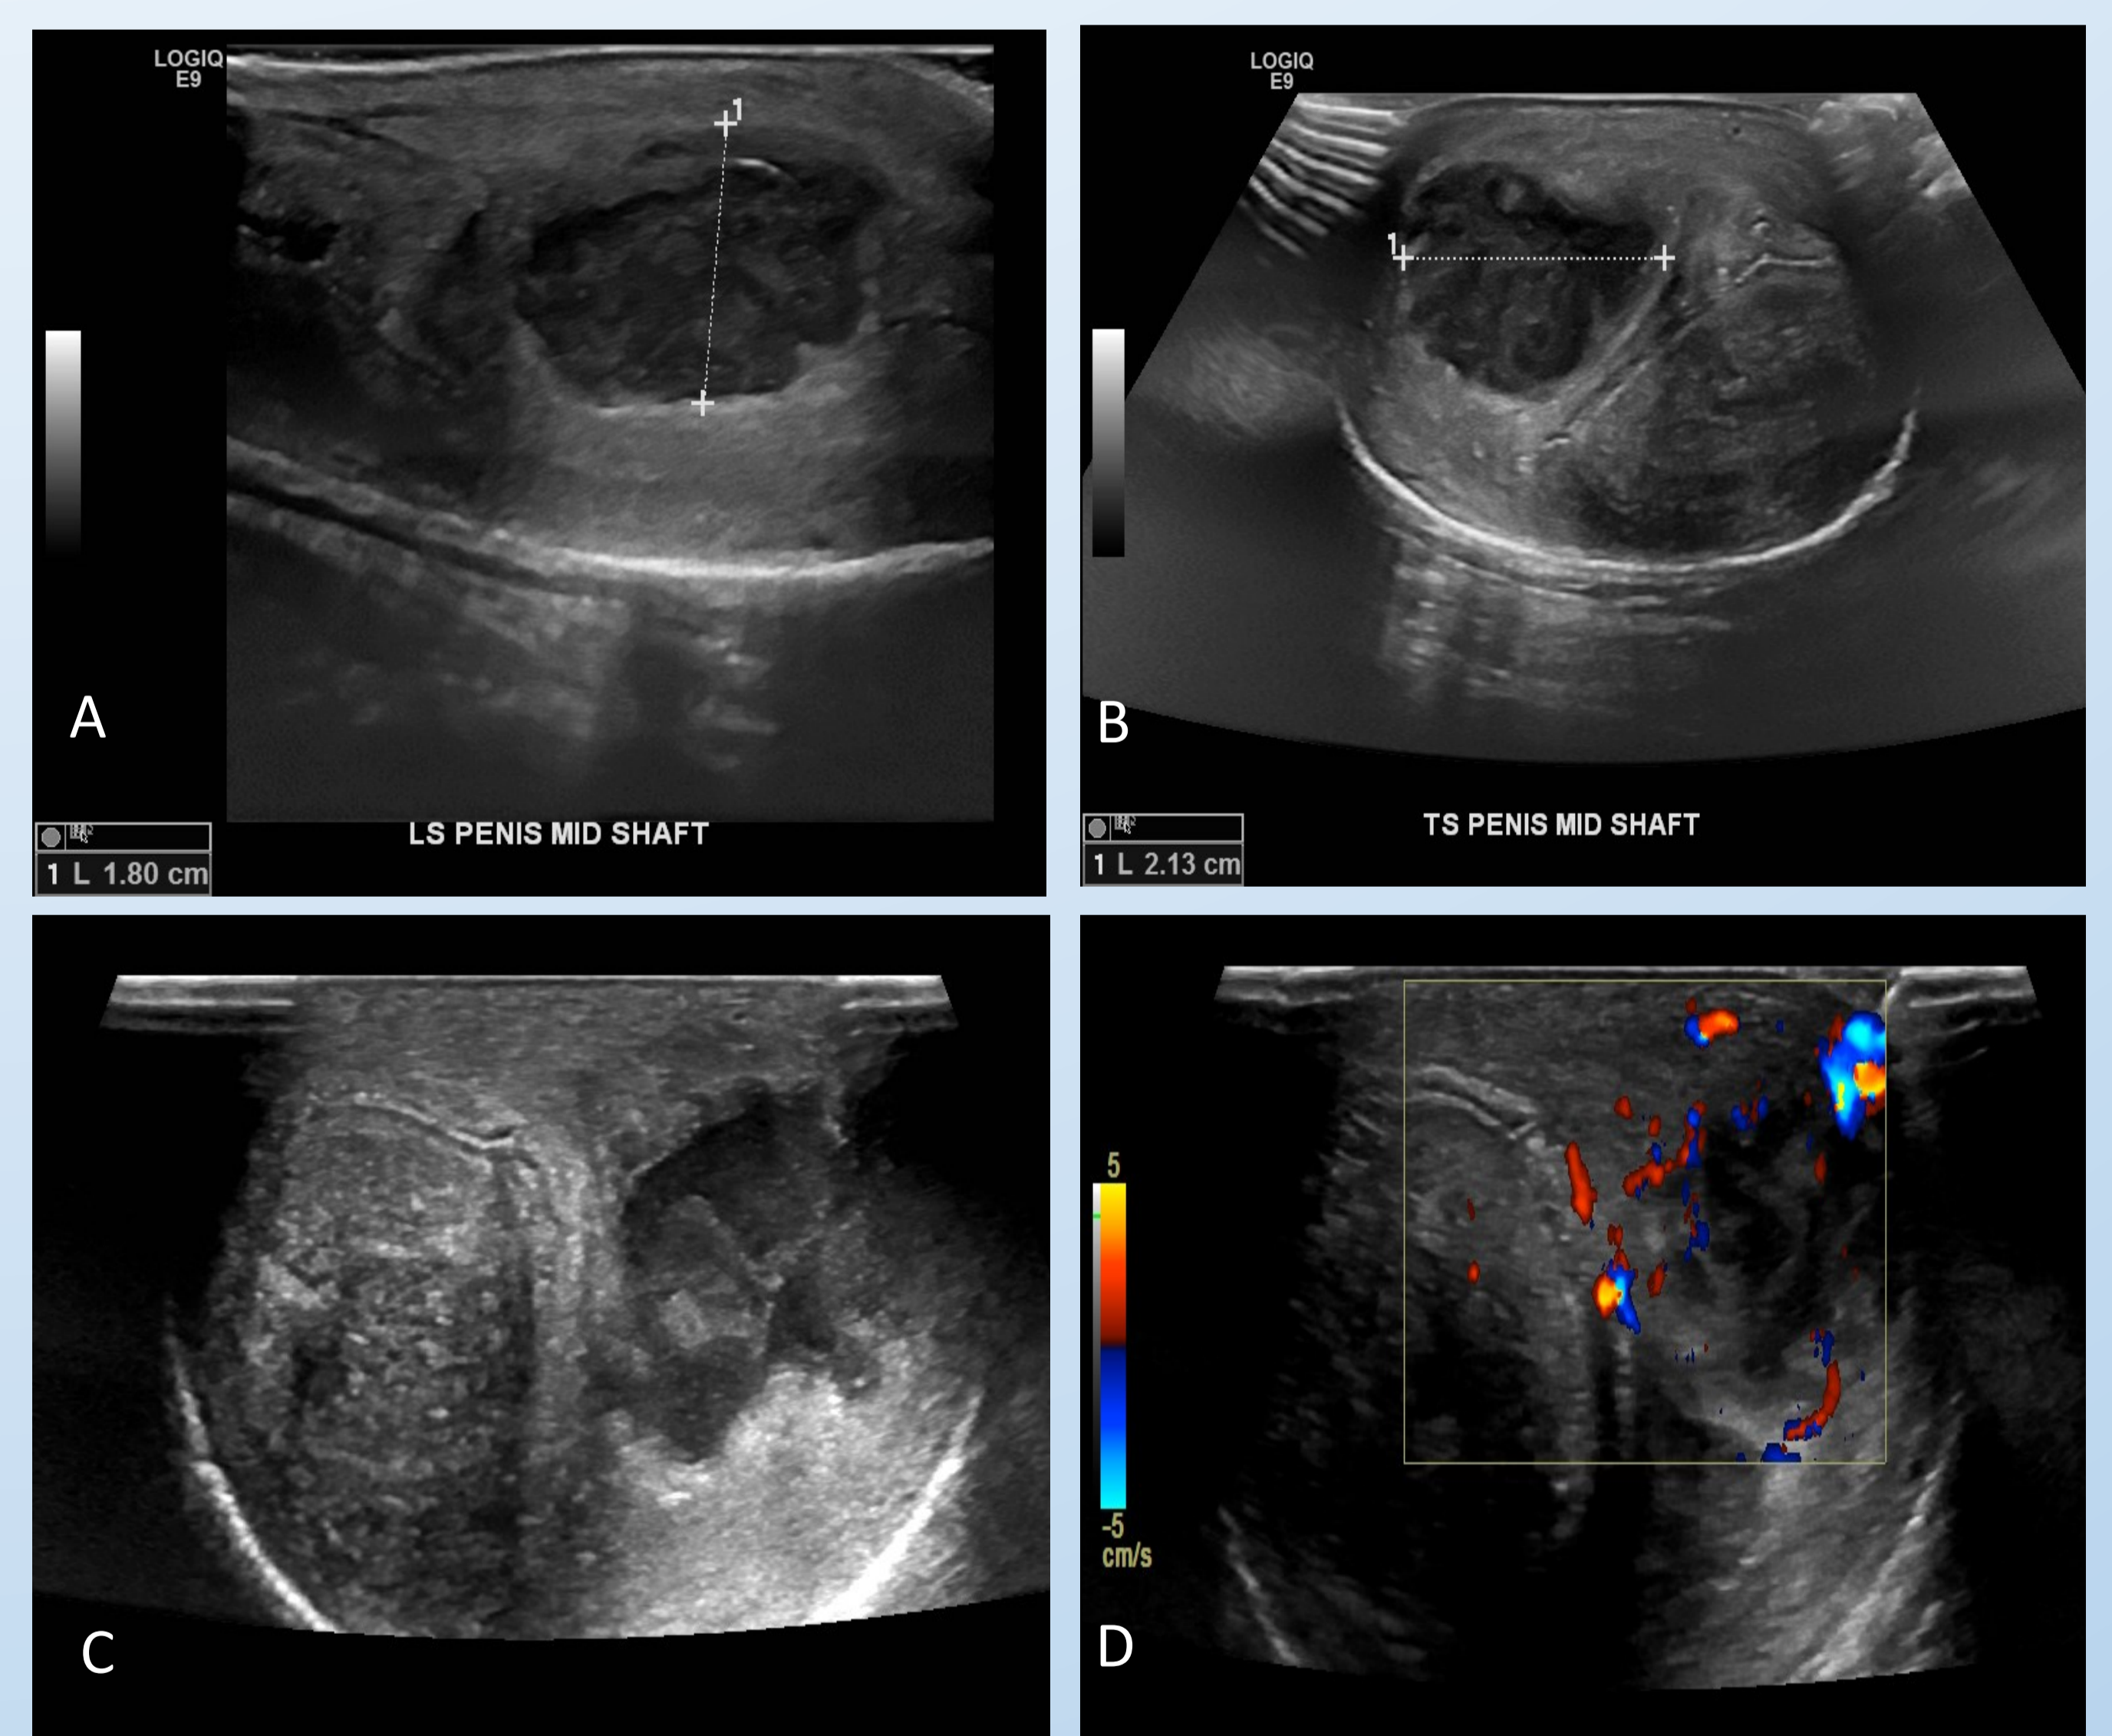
Penile ultrasound. A, longitudinal shows an hypoechoic mid-shaft corporal lesion; B, transverse shows a corporal lesion. C, transverse B-mode, shows deep corpora cavernosa abscess; D, shows no blood flow in the abscess
